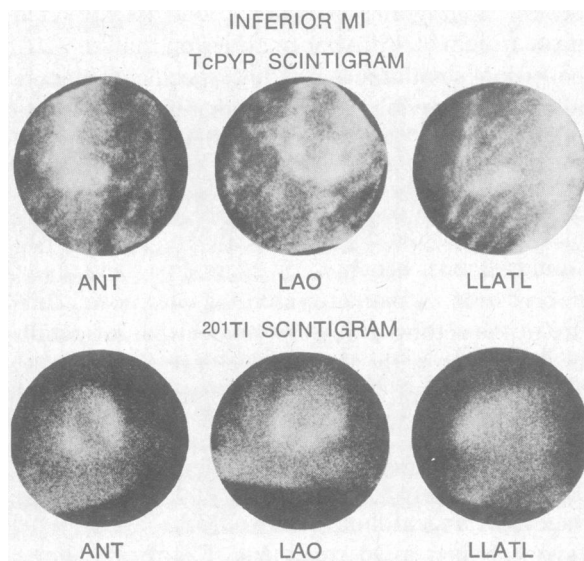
Combined imaging. Shown in the upper panel are the TcPYP infarct scintigrams from a patient with acute transmural inferior infarction. There is a plate-like accumulation of radionuclide extending leftward from the sternum. The lower panel shows the TI-201 scintigrams done at rest in the same patient. An area of relative hypoperfusion involving the inferior left ventricular wall is noted in all three projections and corresponds to the area of discrete TcPYP uptake in the infarct scintigram.
